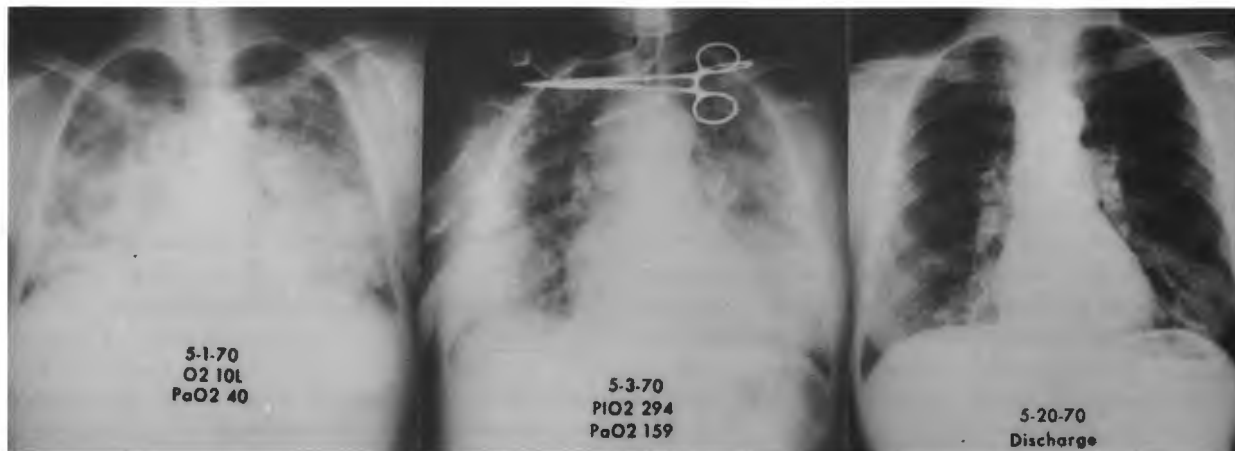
(left)—Bilateral pulmonary infiltration on admission. Severe hypoxemia— PaO_2 , 40 in spite of 10 L nasal oxygen flow (Case 2). Fig. 5 (center)—Clearing pulmonary infiltrate and evidence of improved oxygen transport (PiO_2 , 294; PaO_2 , 159) (Case 2). Fig. 6 (right)—Normal chest x-ray on discharge (Case 2).
